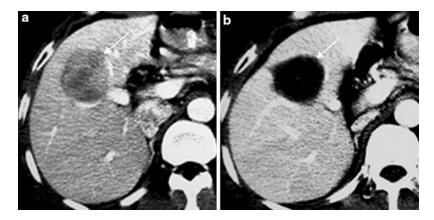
Transverse contrast-enhanced CT scans in a patient who underwent multi-pronged PEI of unfavorable HCC. (a) Portal venous phase preablation image shows a 4.1×4.5 -cm tumor (*arrow*) located above bifurcation of left and right portal veins. (b) Image obtained
